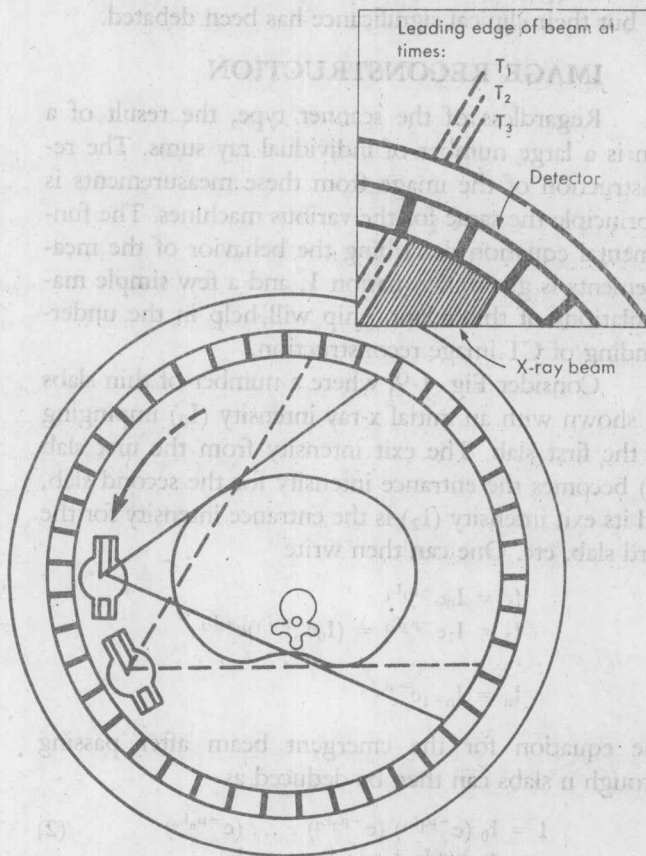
Overlapped measurements. Leading edge of the x-ray beam is shown at three different times ( $T_1$ ,  $T_2$ , and  $T_3$ ) during a scan. Differencing the detector response for the various contiguous intervals yields equivalent nonoverlapped ray projections.
